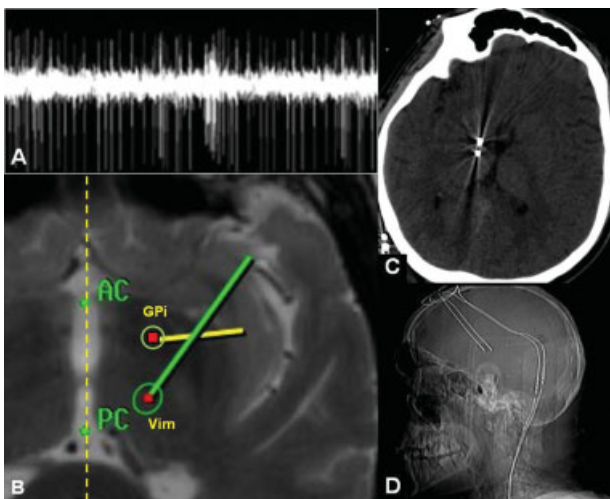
(A) Intraoperative MRI showing the stereotactically targeted right GPi and Vim, and the planned trajectory of the electrodes. (B) MER of the right GPi demonstrating the burst pattern. (C) Postoperative brain CT scan and (D) lateral plain radiograph showing the final position of the electrodes in the right GPi and Vim. CT, computed tomography; GPi, globus pallidus internus; MER, microelectrode recording; MRI, magnetic resonance imaging; Vim, ventral intermediate thalamic nucleus.
